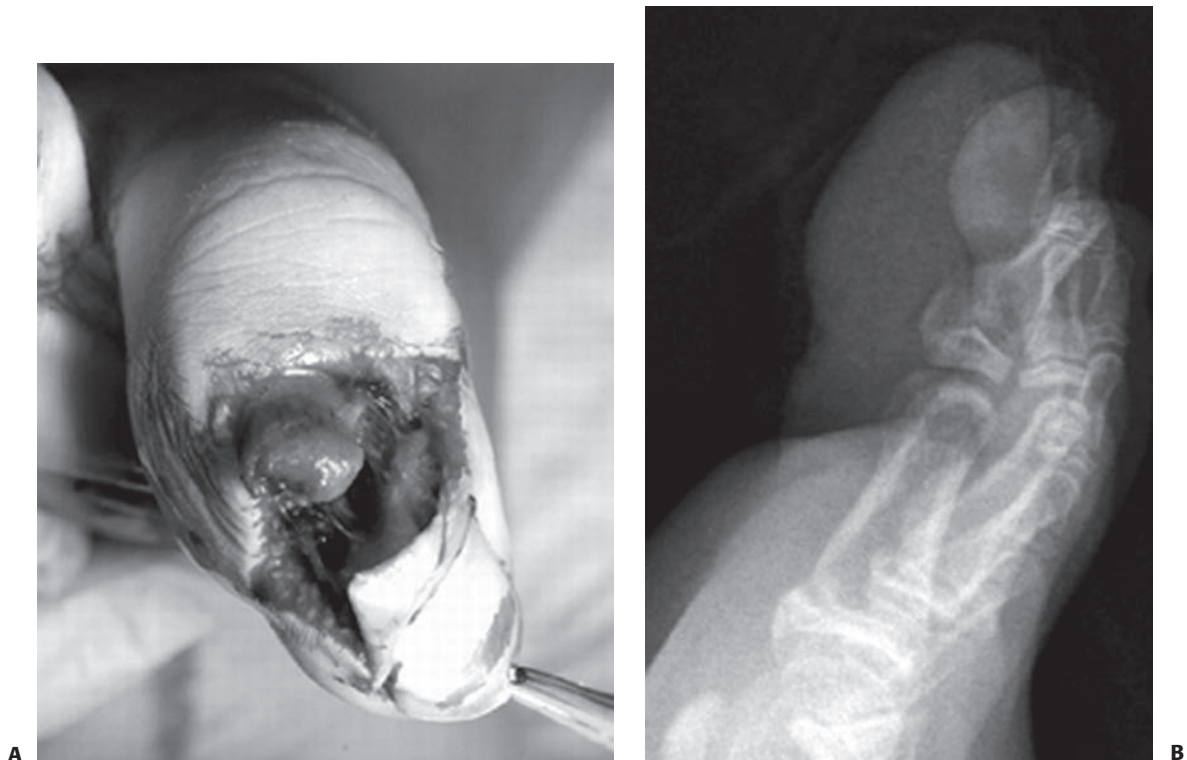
A: This 7-year-old boy “stubbed” his toe barefoot on his bike and sustained an open fracture of the tuft of the distal phalanx and associated laceration of the germinal matrix. B: Preoperative radiograph shows the small tuft fracture.
